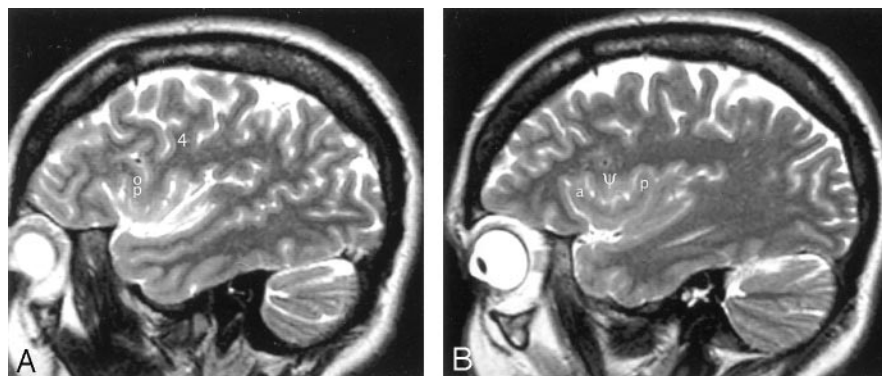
A and B, Sagittal T2-weighted MR images of the left hemisphere in a 34-year-old woman show the opercular-insular relationship. The union of the pars opercularis (op) of the inferior frontal gyrus with the inferior end of the precentral gyrus (4) forms a very bulky "pseudomass" (Ø) that invaginates into the convexity surface of the anterior lobule, depresses the insular surface at the MSG, and splays the ASG (a) apart from the PSG (p). (See also Figs 1 and 3.)
